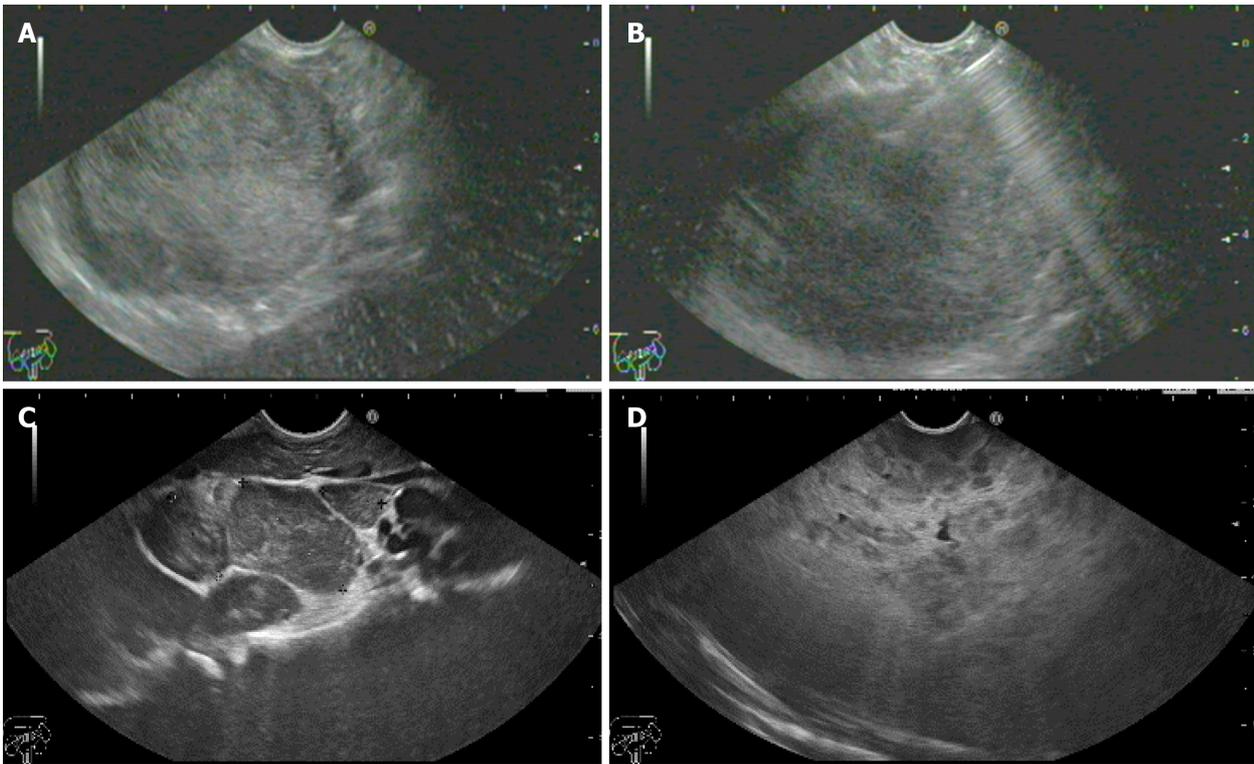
Endoscopic ultrasound. A and B: Solid pseudopapillary neoplasm with fine needle aspiration; C and D: Mediastinal lymph nodes with multiple splenic focal lesions diagnosed as lymphoma.
